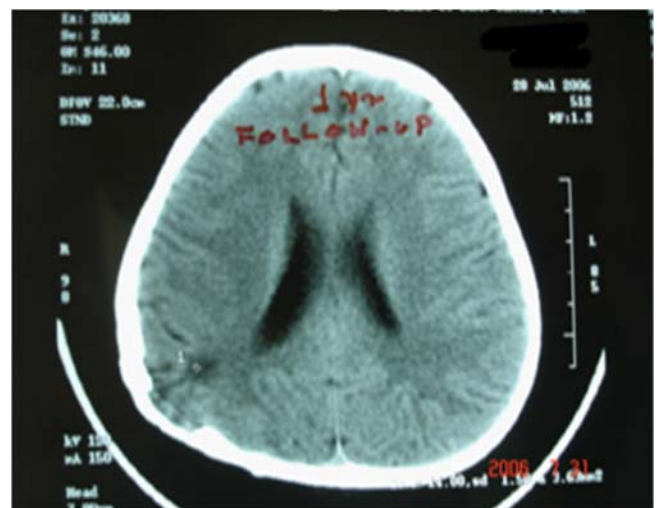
One year post-operative follow up A) radiograph and B) CT scan showing significant obliteration of the right parietal defect
